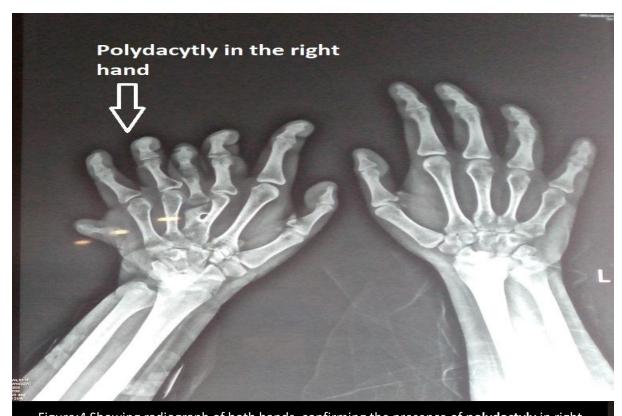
4 Showing radiograph of both hands, confirming the presence of polydactyly in right VEN=1
